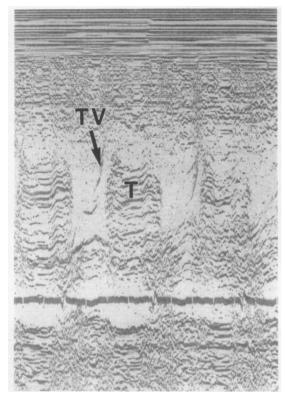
M mode echocardiogram of the tricuspid valve (TV). Tumour echoes (T) are seen behind the leaflets. The echo producing structure nearly fills the ostium during diastole.
